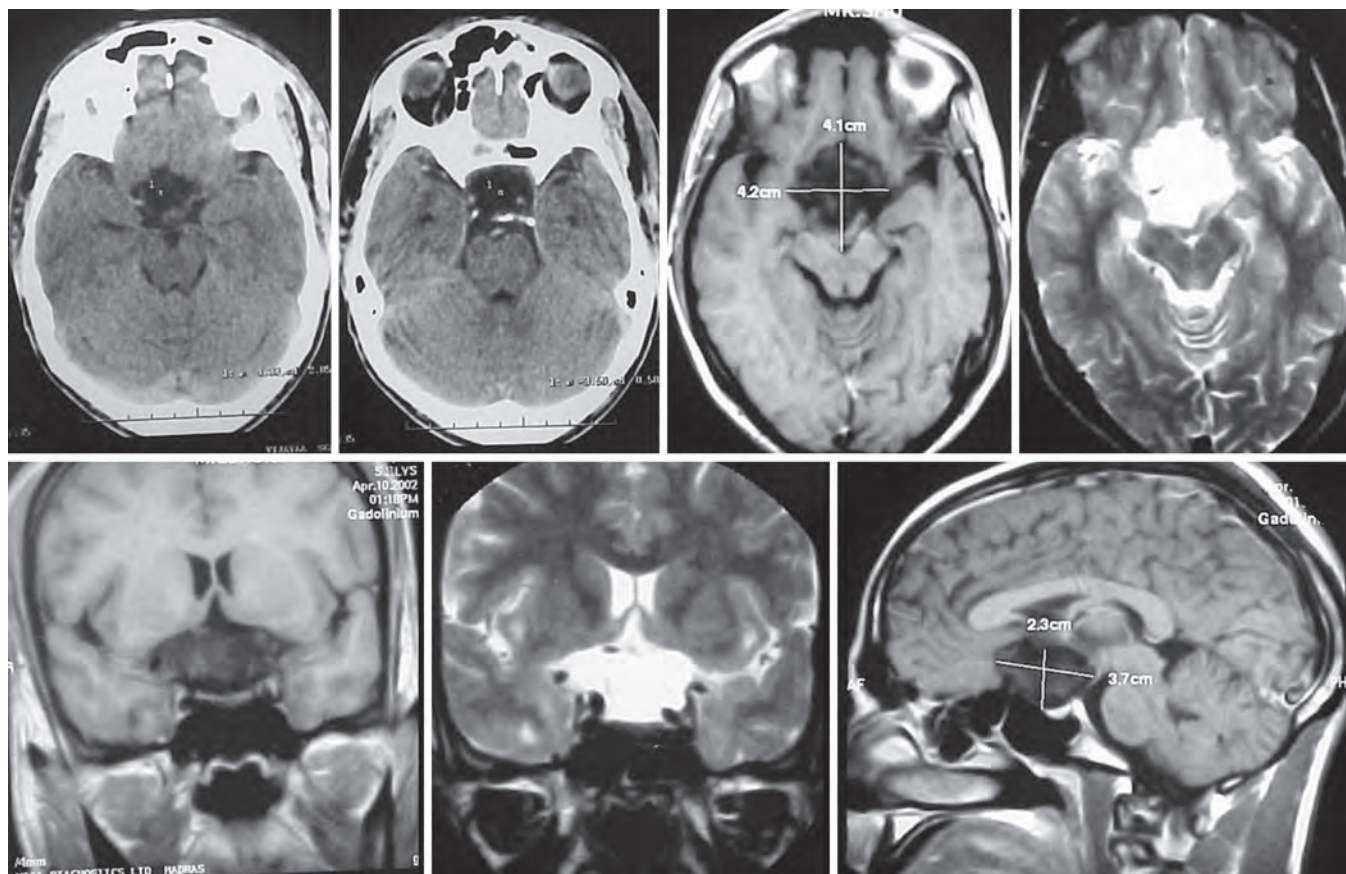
CT scan of the brain showing epidermoid in the suprasellar region which is hypodense. MRI scan of the brain showing the lesion which is hypointense on T1- and hyperintense on T2-weighted images
